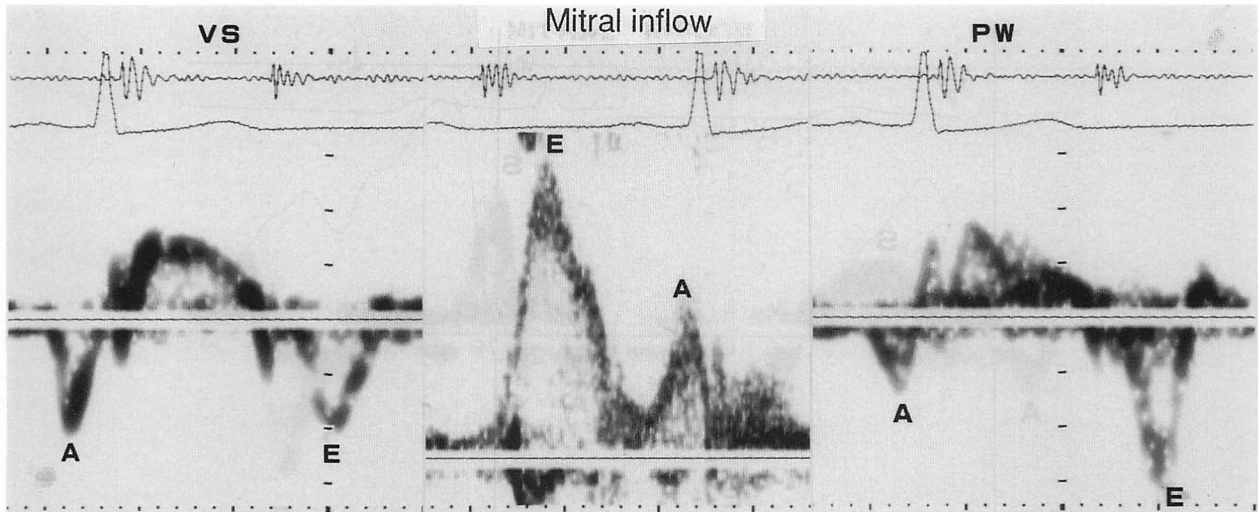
Representative Doppler tracings showing relationships of the A/E ratio between wall motion velocities and mitral inflow (30-year-old normal subject)
